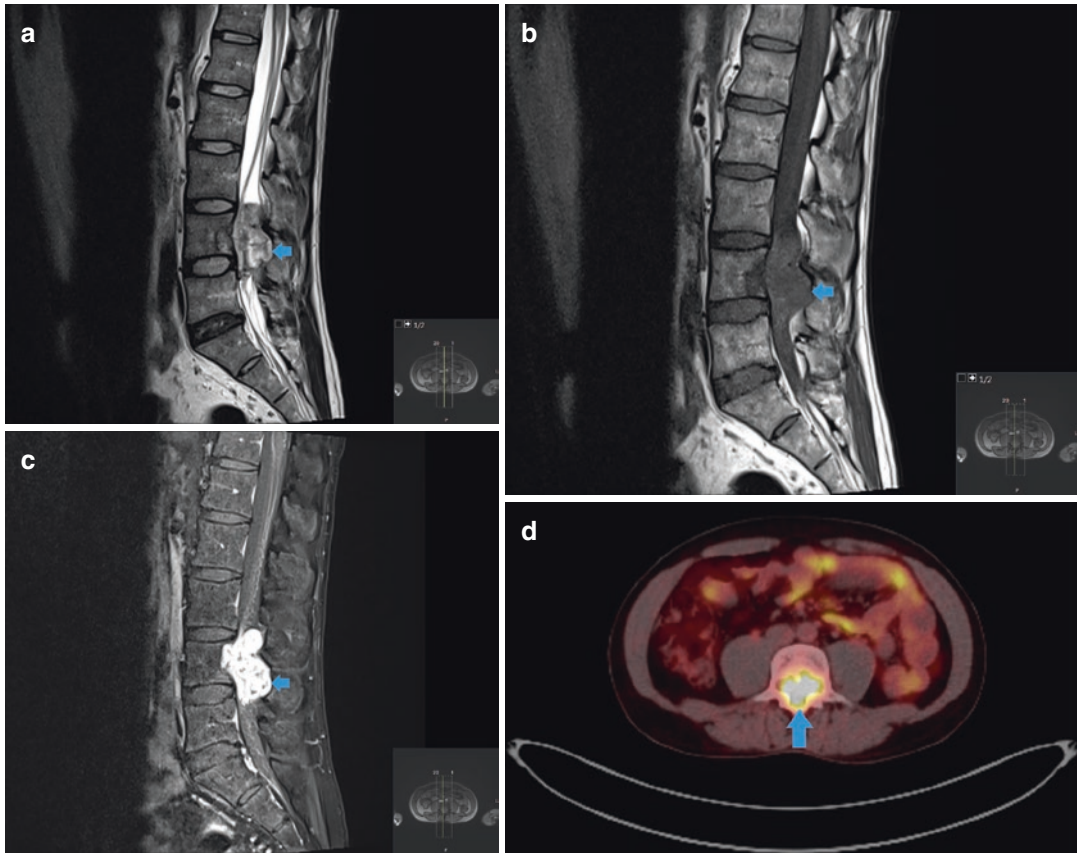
Paranglioma. Figure 9.13a is a sagittal T2-weighted MR image showing a heterogeneous intradural extramedullary mass arising below the conus medullaris, and causing mass effect on the cauda equina, expansion of the spinal canal, and smooth bony remodeling of the adjacent vertebral bodies (arrow). Figures 9.13b
